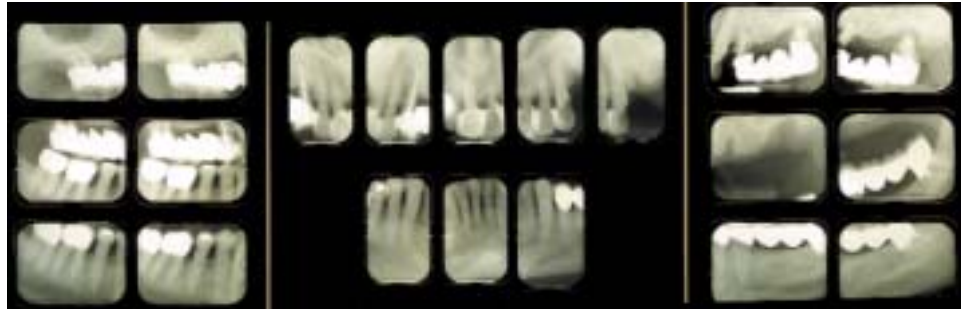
Full mouth initial radiographs
